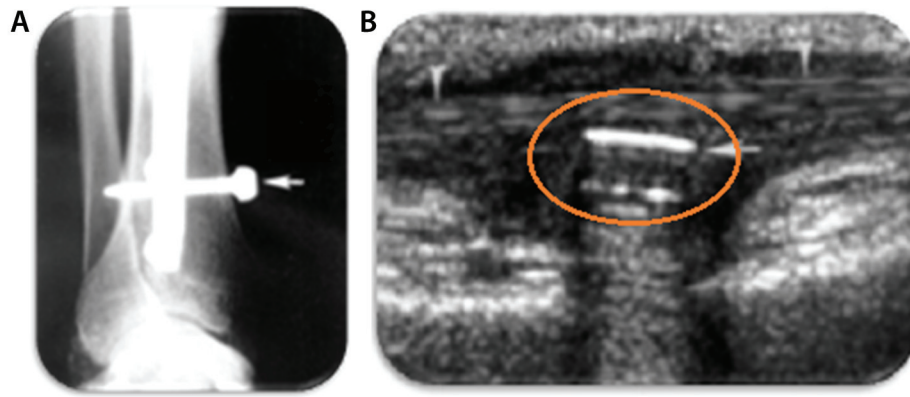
(A) Lateral view and (B) USG picture of a case with partial rupture of tibialis anterior tendon. Note presence of distal locking screw marked on a radiograph with arrow. Note circle marked on USG is showing tendon rupture.
